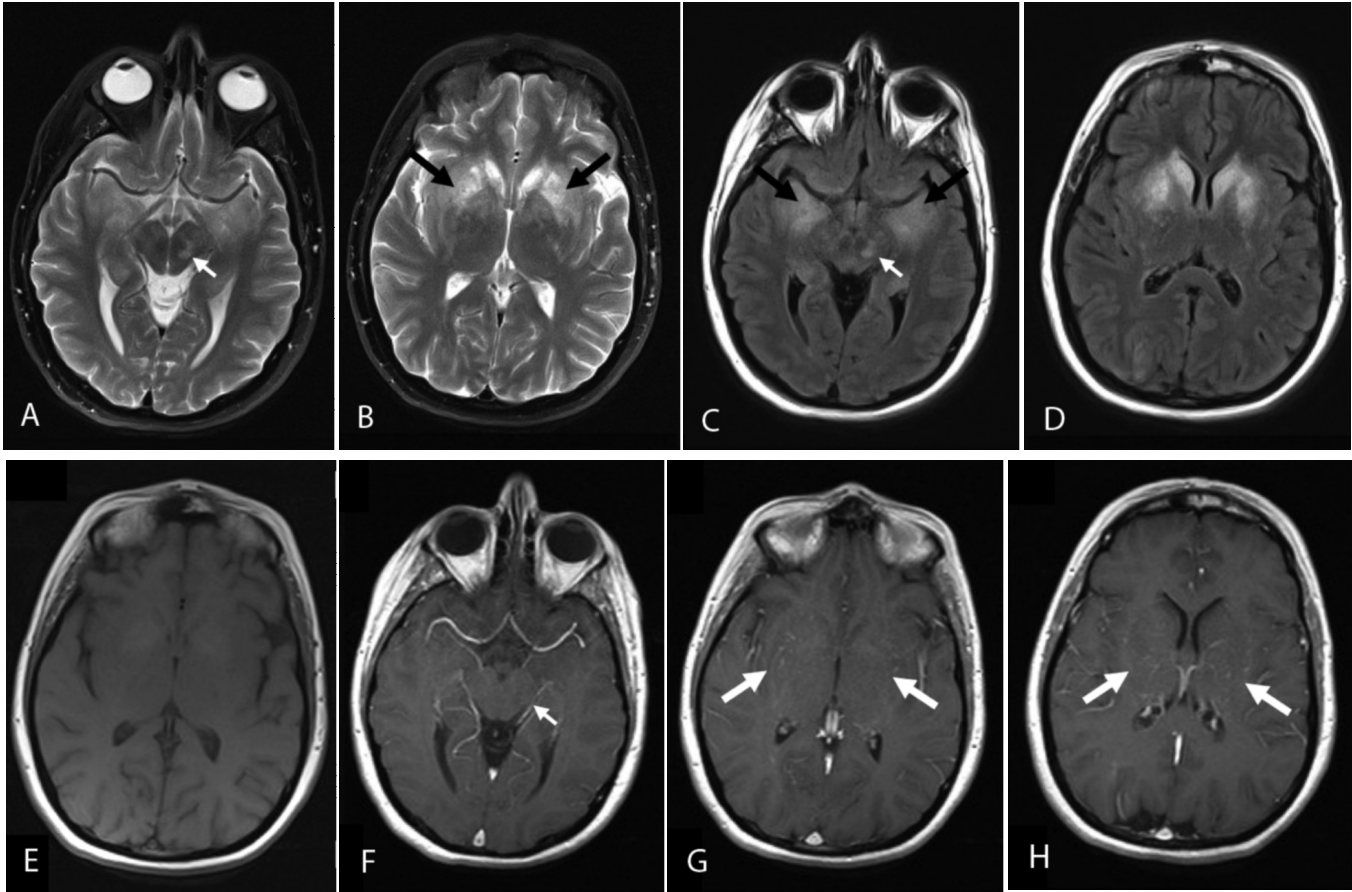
37-year-old female with Hashimoto's encephalopathy. Brain MRI performed six months after the onset of symptoms. Axial T2 (A and B) and axial FLAIR (C and D) show symmetric and bilateral areas of abnormal high signal on T2-weighted and fluid attenuation inversion recovery (FLAIR) images involving the mesial temporal lobes, caudate nuclei, and putamina (black arrows). The basal ganglia lesions are minimally hyperintense on T1-weighted images (E). These lesions have fine serpiginous enhancement on T1-weighted postcontrast images (G and H) (white arrows). Additionally, a left midbrain lesion, hyperintense on T2-weighted and FLAIR images (A and C), shows no enhancement after gadolinium administration (F) (small arrows).
